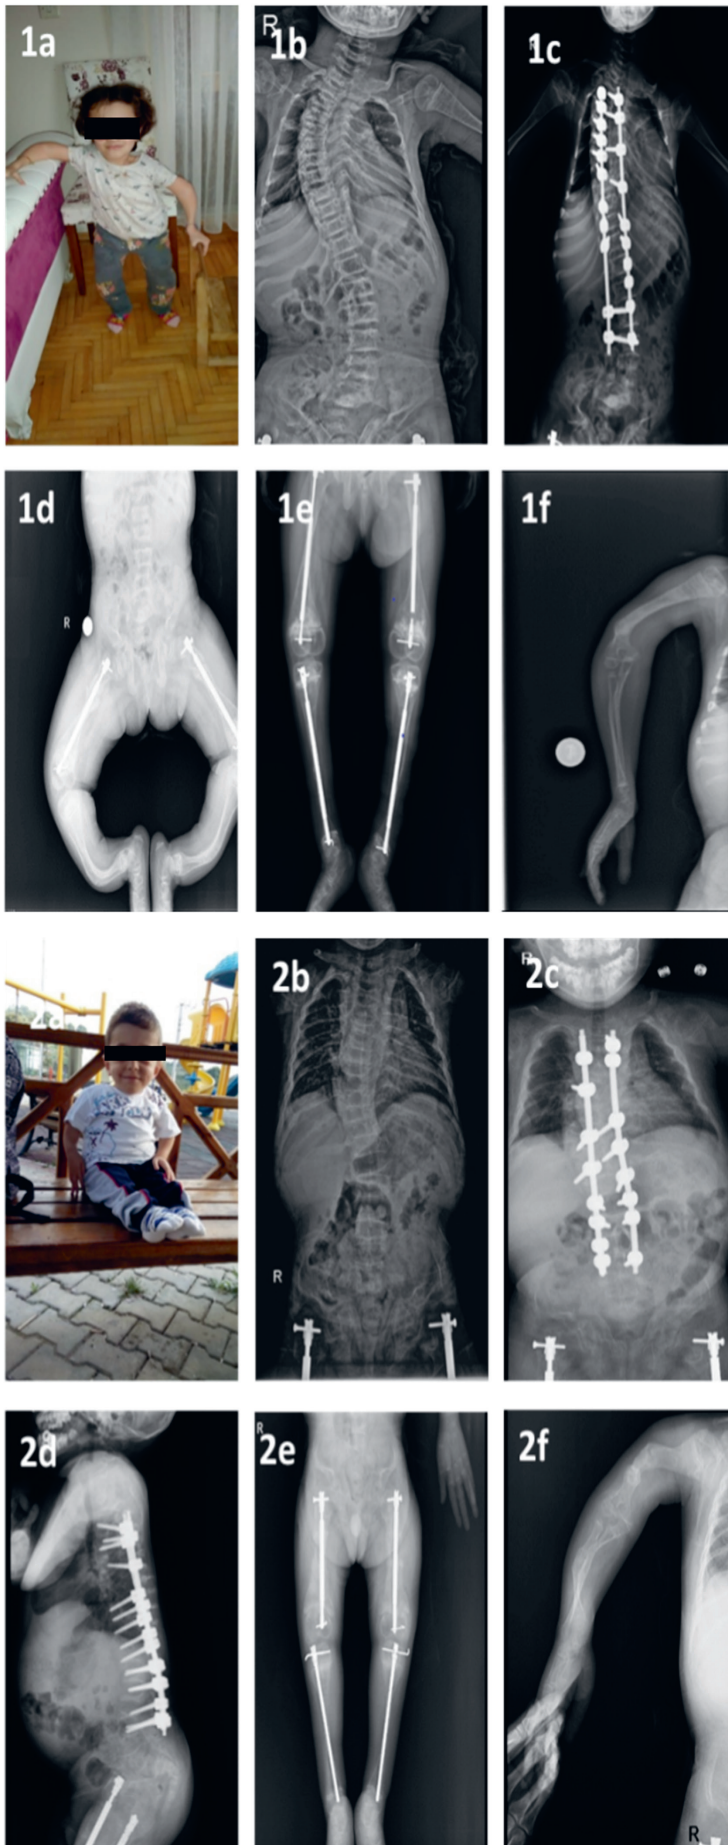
Autosomal recessive osteogenesis imperfecta (OI) phenotype due to P3H1 mutations (clinical presentation and skeletal graphs). Severe scoliosis, asymmetry of the lower limbs, thin bones, and severe deformities in the femurs, tibias and fibulas were observed. 1a. Clinical pictures of case 1 (11 years and 7 months of age: walks and stands with assistance); 2a. Clinical pictures of case 2 (9 years and 3 months of age: walks and stands with assistance); 1b and 2b. Anteroposterior (AP) view of the thoracolumbar spine on radiography; 1c and 2c. The AP view of thoracolumbar scoliosis on a radiograph taken postoperatively; 1d. Bilateral tibia and fibula showing anterolateral curvatures; 2d. Lateral view of thoracolumbar scoliosis on a radiograph taken postoperatively; 1e and 2e. Postoperative radiographic images showing nailing and healing of the fracture; 1f and 2f. Severe deformities of the upper limbs. Informed consent was obtained from the patients prior to publishing these images
